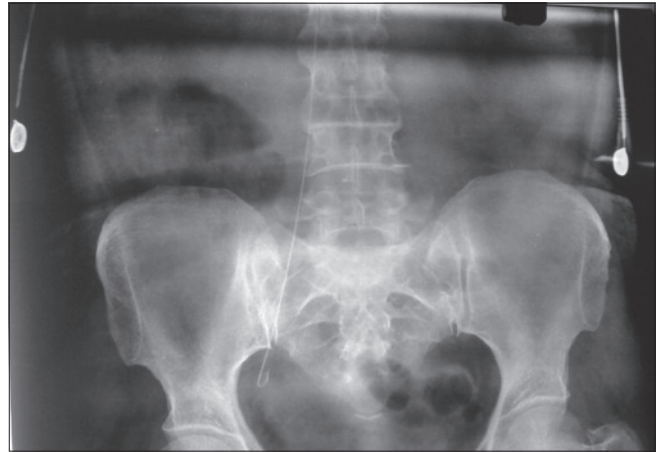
X-ray pelvis showing guide wire catheter had remained in the right iliac vein at the point of bifurcation into the internal and external iliac veins
